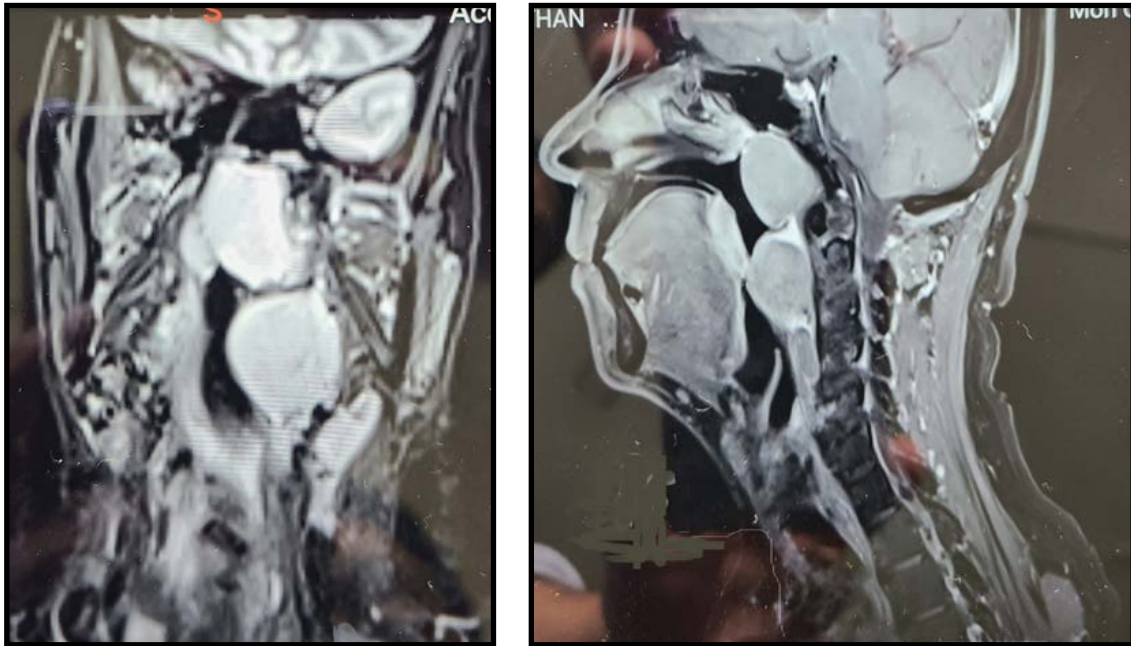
Coronal and sagittal sections of MRI shows two separate lesions in the nasopharynx and left side parapharyngeal space
